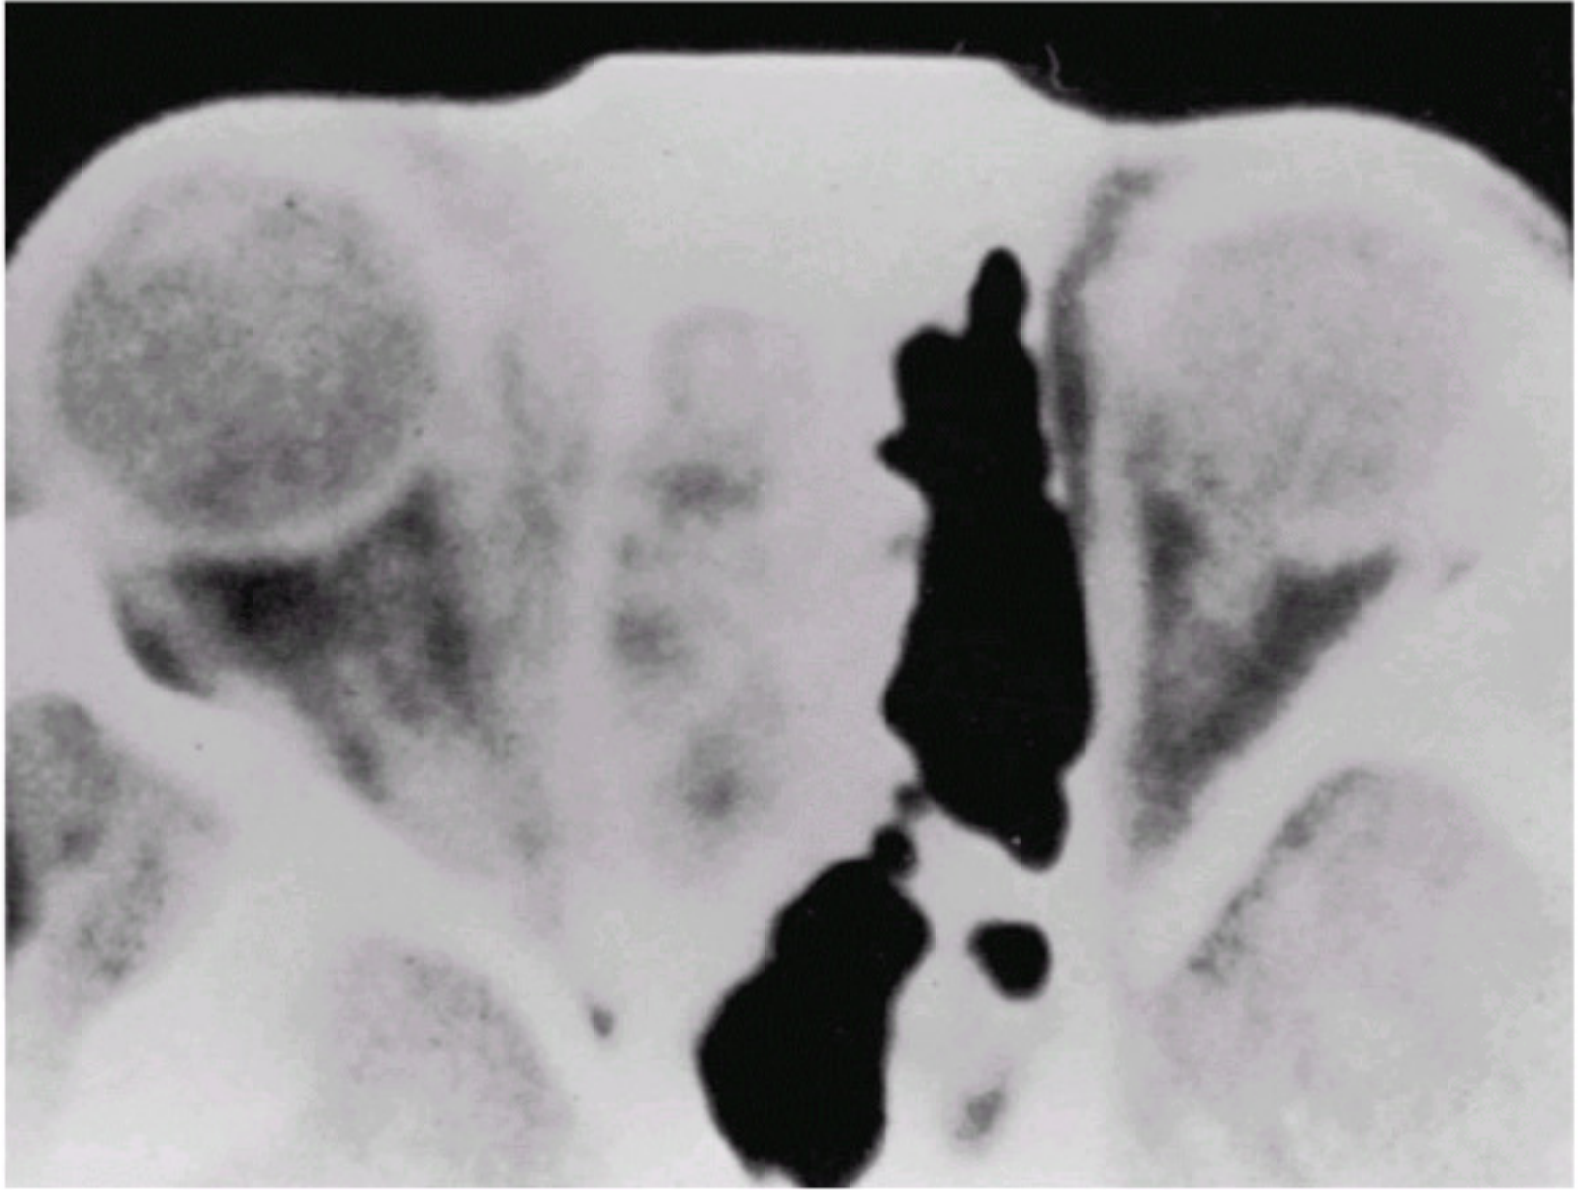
Axial computed tomography scan showing edema of the lids and subcutaneous tissues anterior to the orbital septum.
